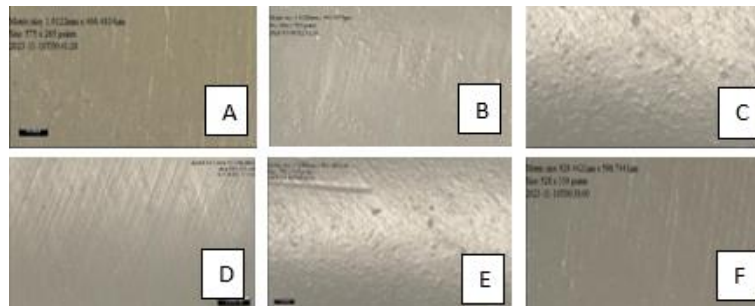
Surface Profilometric Images Of Group 1 – Omnichroma : A- After Initial Finishing And Polishing, B – After Thermocycling, C – After Manual Instrumentation, D – After Ultrasonic Instrumentation, E – Post Prophylactic Polishing (Manual Instrumentation Group) And F - Post Prophylactic Polishing (Ultrasonic Instrumentation Group)
